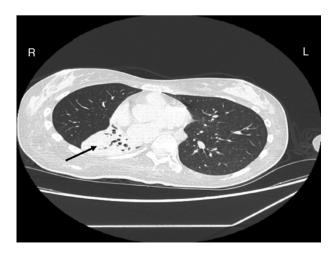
Chest CT scan at admission: atelectasis of the lower right lobe.
